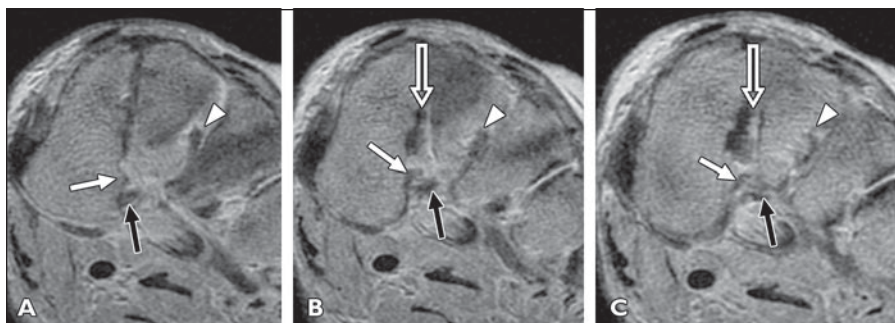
Plantar Lisfranc ligament with two bands arising separately from C1. A–C, Consecutive coronal proton density MR images after injection of intraarticular gadolinium solution show plantar Lisfranc ligament formed by two separate bands that did not show common C1 insertion. Instead, each band had its own insertion (M2 band of plantar Lisfranc ligament—white arrows and M3 band of plantar Lisfranc ligament—black arrows). Lisfranc ligament (white open arrows) and second interosseous cuneometatarsal ligament (white arrowheads) are also depicted.
